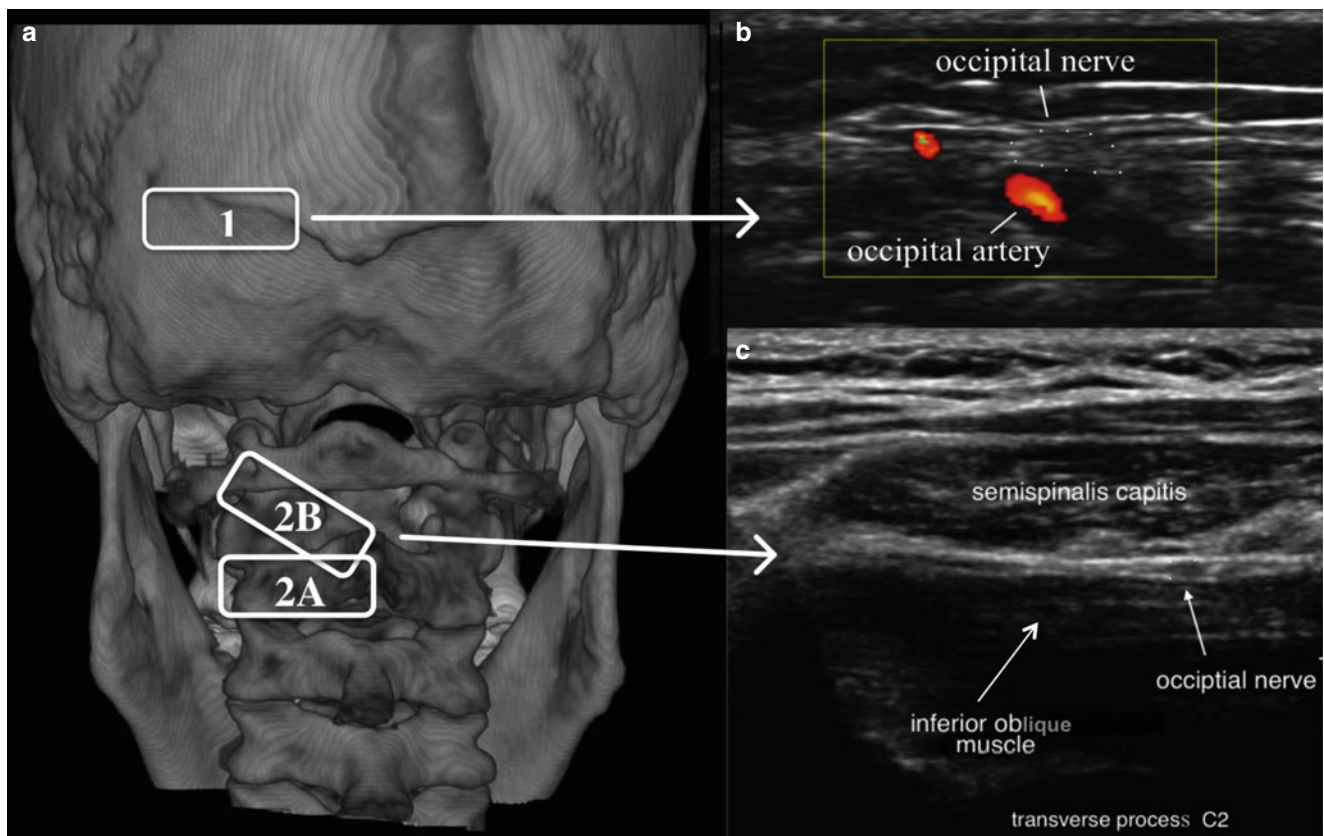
Ultrasound identification of the greater occipital nerve. (a) Location of ultrasound transducer: 1 distal occipital nerve ultrasound site at nuchal ridge; 2 proximal occipital US approach with (2A) being the initial probe placement and (2B) being the final probe placement.
